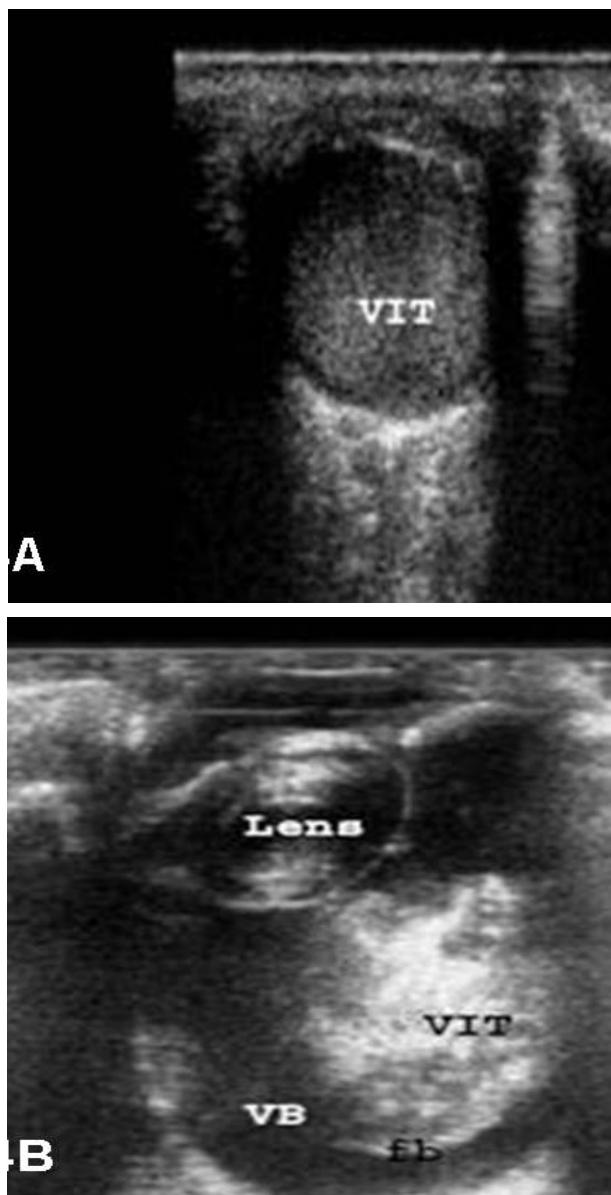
Ultrasonography image (C-7.5 and D-18 MHz linear probe) showing extensive vitreous hemorrhage. A: Diffuse, multifocal evenly dispersed echoes are present in the vitreous chamber with motion on real time examination suggesting vitreous hemorrhage (VIT). Vitreous hemorrhage is organized and developed into fibrinous membranes (fb). B: Vitreous body-VB
